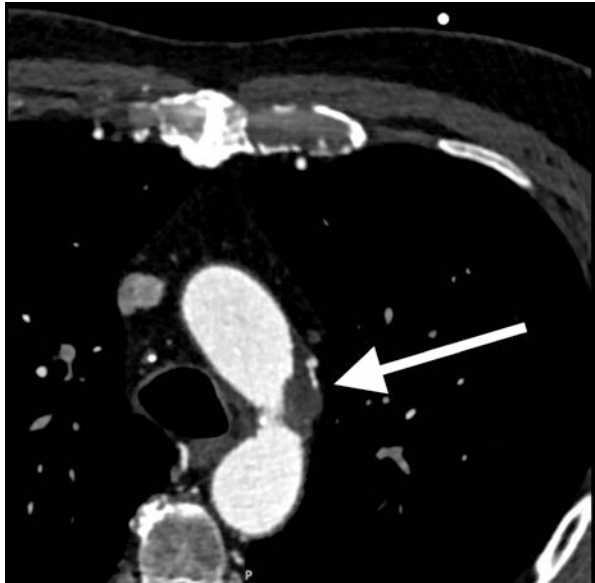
CT angiography transverse projection of a patient with an acute aortic dissection. The arrow shows the tear extending along the aortic arch
